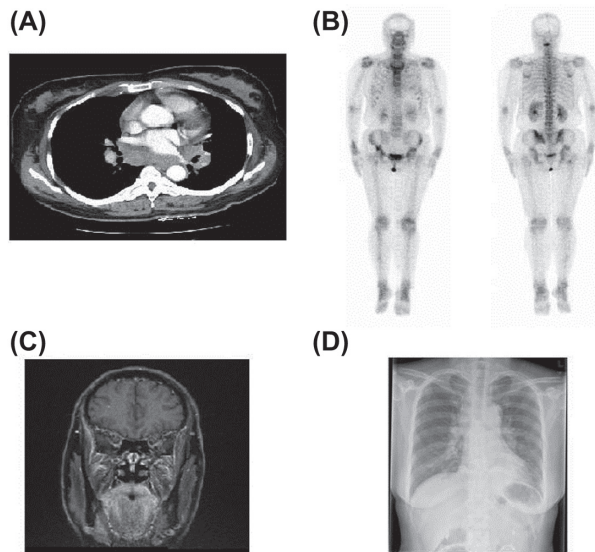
(A) CT scan shows occupying lesion in the posterior basal segment of the left lung. (B) Bone ECT reveals radial enhancement of the left hip. (C) Cerebral MRI demonstrates abnormally high intensity in the left frontal lobe. (D) Anterior posterior chest radiograph shows occupying lesion in the lower left lung and the presence of multiple foci in both lungs.
